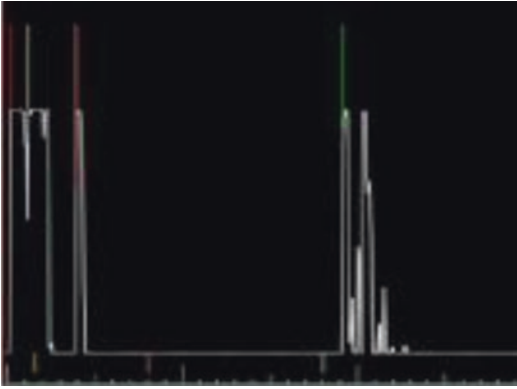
A-mode display for eye ultrasound
